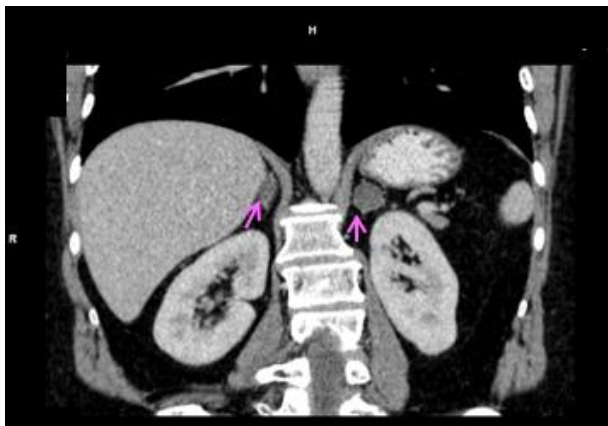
Abdominal computed tomography (with contrast) aspect (coronal plane): bilateral adrenal tumours (arrows)
